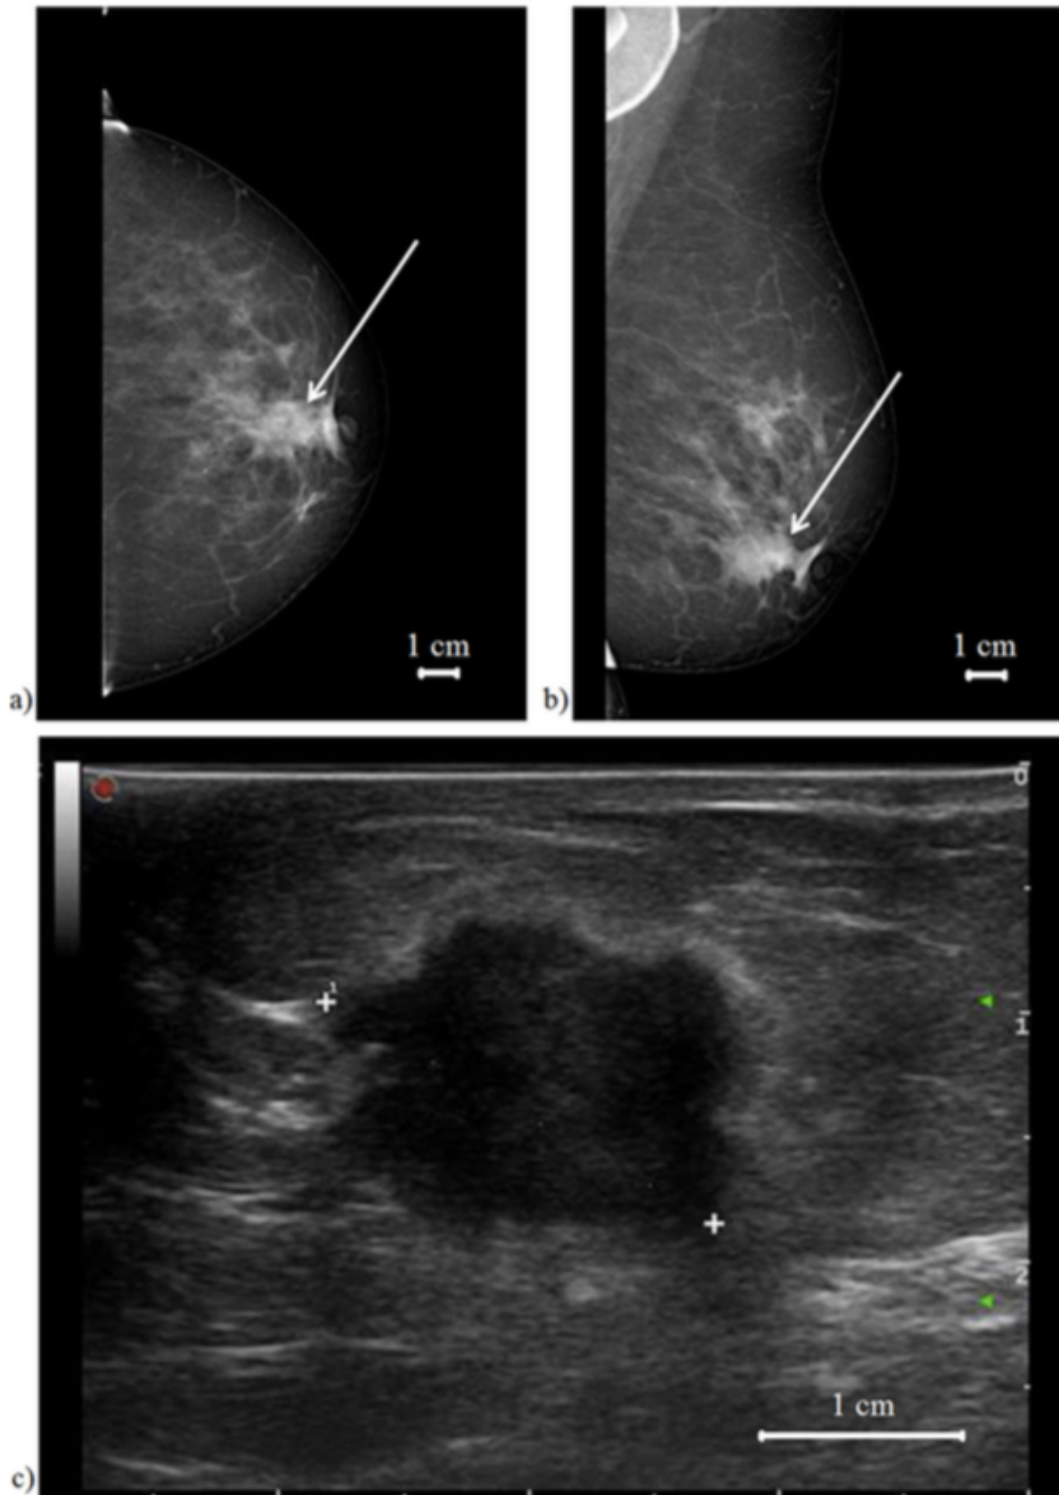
Mammographic and ultrasound images of the breast prior to mastectomy. (a) Digital mammography - the cranio-caudal view (CC) image; (b) Digital mammography - the mediolateral oblique view (MLO) image; (c) result of ultrasonography examination.
